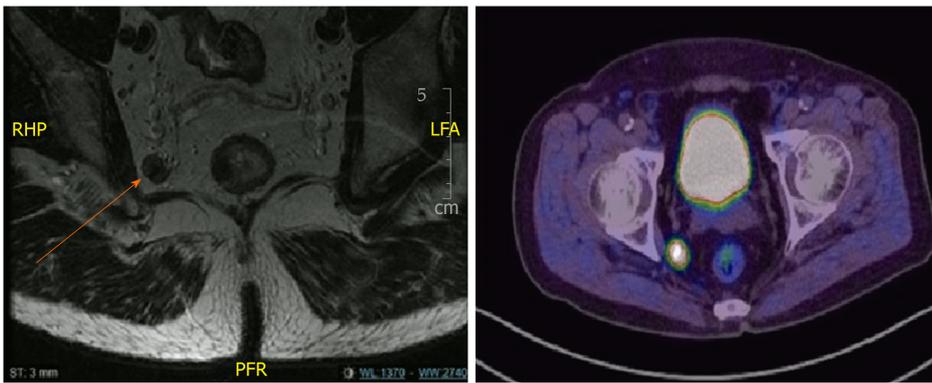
Metastatic lateral pelvic lymph node seen on magnetic resonance imaging rectum and positron emission tomography scan.
